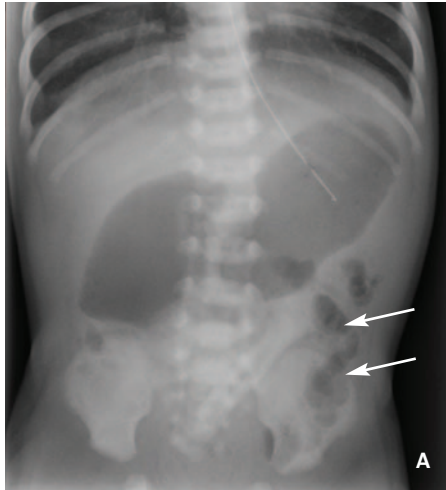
A one-day-old baby born at term with bilious vomiting and suspected sepsis. (A) A plain X-ray showing the double bubble appearance with gas seen in the jejunal loops (arrows). (B) An upper GI contrast study with contrast opacification of the stomach and dilatation of the first part of the duodenum (D1). There is circumferential narrowing of the second part of the duodenum (D2) and the duodenum crosses the midline (this excludes malrotation).
